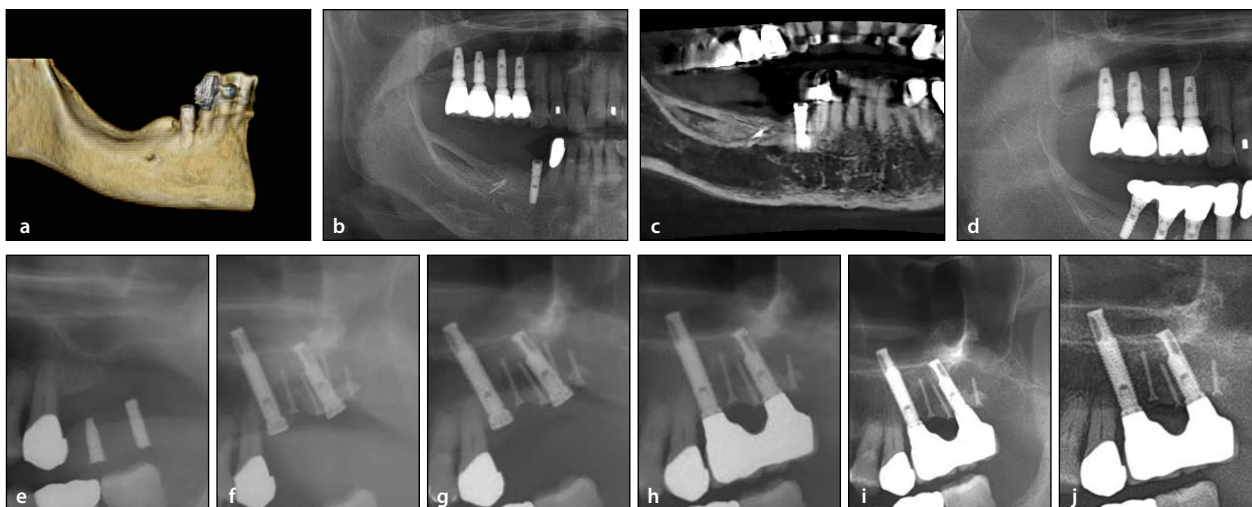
Radiographs of the two patients with a large amount of vertical bone gain. (a) Preoperative 3D reconstruction of the CT. (b) Panoramic radiograph after onlay graft with right mandibular ramus. (c) CT taken 6 months after implant placement shows integration of the graft bone and new bone formation of the gap between the alveolar bone and grafted bone. (d) Panoramic radiograph taken 2 years after the placement of the implant. (e) Panoramic radiograph of another patient with vertical defect in left maxillary posterior area. (f) Panoramic radiograph after two-block onlay graft. Implants were placed simultaneously. Panoramic radiograph taken (g) 6 months, (h) 1.5 years, (i) 3 years, and (j) 5 years after the placement of the implant.
